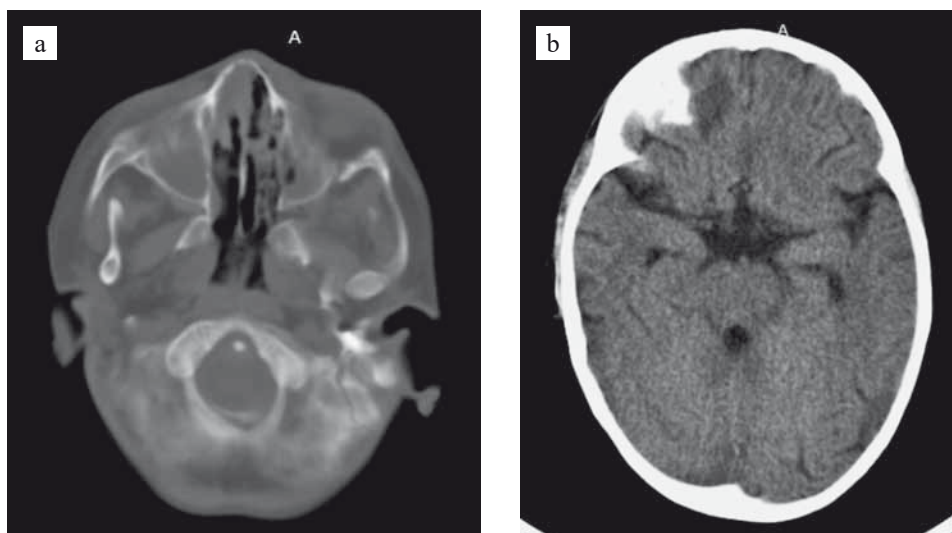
CT scan: a, of paranasal sinuses; b, of brain
